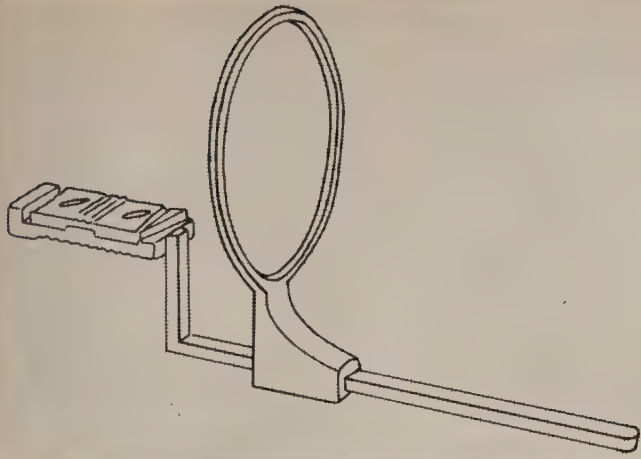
Instrument for anterior teeth used in the long cone paralleling technique. (Updegrave, W.J. New horizons in periapical radiography. Rinn Corporation.)
